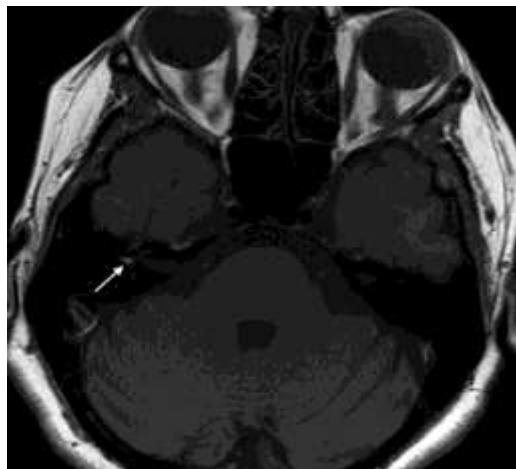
Labyrinthine concussion; axial T1-weighted spin echo sequence shows a small spot of T1 shortening (arrow) due to intra-labyrinthine haemorrhage in a patient with unremarkable CT examination after a head trauma.
